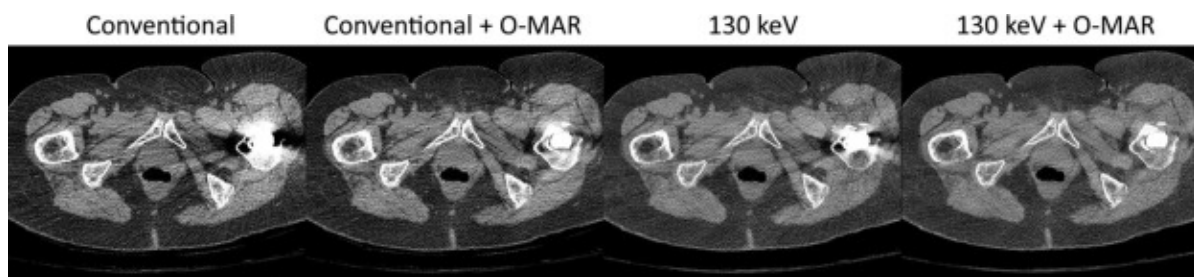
CT scan with unilateral hip arthroplasty demonstrating the effect of dedicated metal artifact reduction software (O-MAR) and virtual monochromatic imaging at 130 keV. In both the O-MAR and 130 keV VMI image, artifacts resulting from the hip implant continue to obscure surrounding tissue. The combination of 130 keV VMI and O-MAR shows superior artifact reduction over both plain O-MAR and VMI. Figure adapted from [48].
